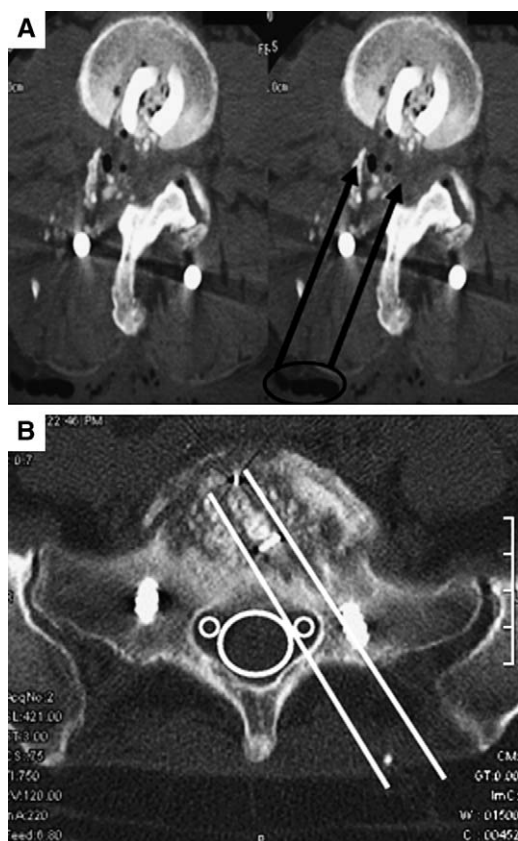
Early postoperative axial CT scans acquired in a patient who underwent an L4-to-L5 microendoscopic TLIF reconstructed with allograft bone (*A*) and in another patient undergoing a minimally invasive TLIF using an interbody cage (*B*). These reveal the location of fascial entry (*black circle*), approach angle of the procedure (*black arrows*), and various treatment options for obtaining interbody fusion. Note how little thecal sac retraction is required to place a graft in when using a paramedian approach to L5 to S1 (*white circle and lines*).
